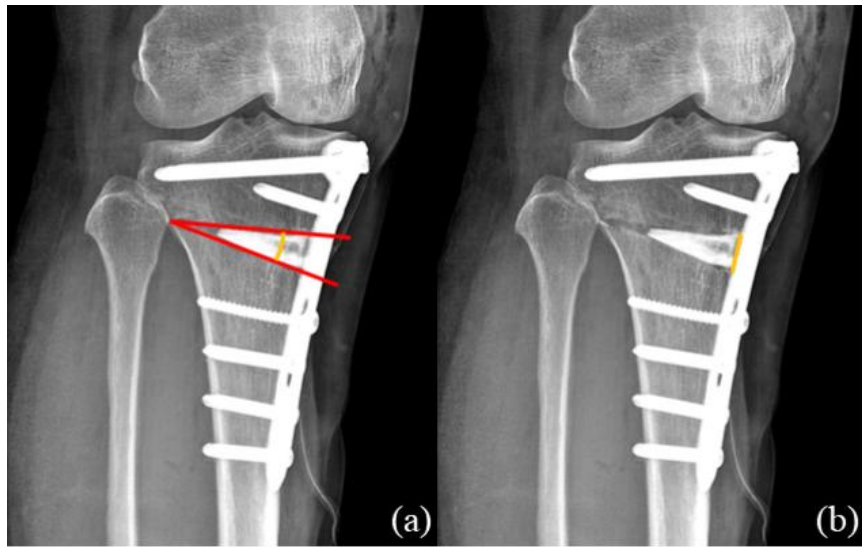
Tibia simple radiograph. (a) correction angle, (b) correction height.
